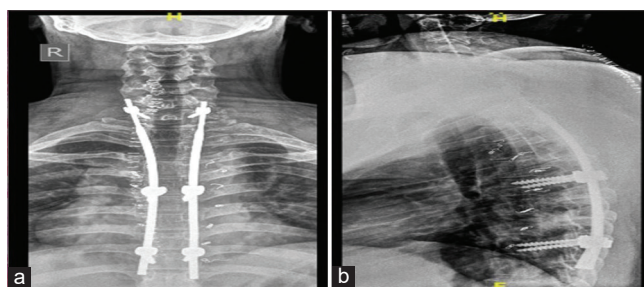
Post op X-ray Dorsal spine (a) AP, (b) Lateral view.
